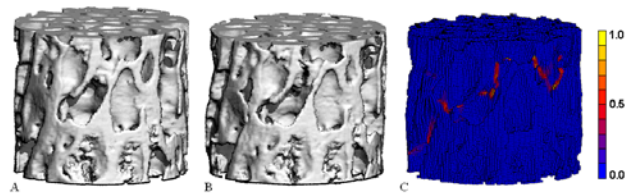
Rendered CT scans of a sample in its initial (A) and deformed (B) state. The deformed  $\mu$ FE mesh (C) is shown for comparison.
